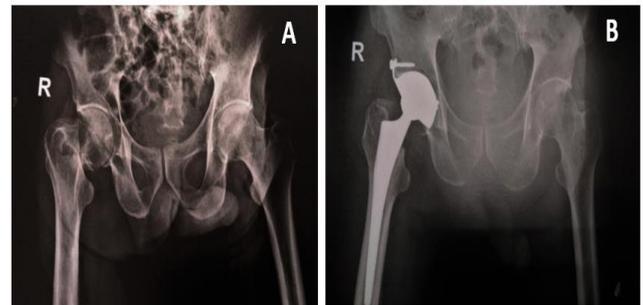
(2A): Pre-operative X-Ray of a 70 years Male, Hypertensive, Diabetic, Psychic Depression, had Fracture neck of right Femur with Osteoarthritic hip and neglected (2B): Post-operative X-Ray of the Dual Mobility THA patient after Cementless
